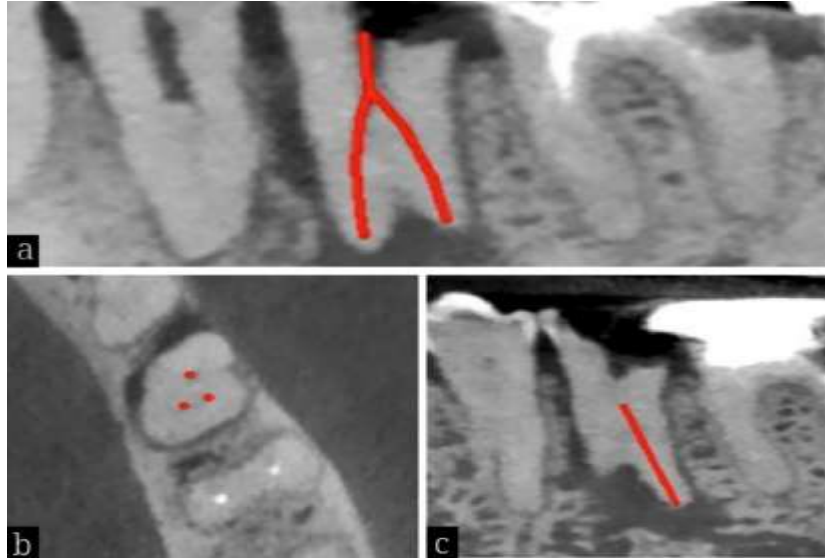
CBCT images (a) Sagittal view – root canals of buccal roots (b) axial section showing the pulp canals (red points) (c) sagittal view – lingual canal.
